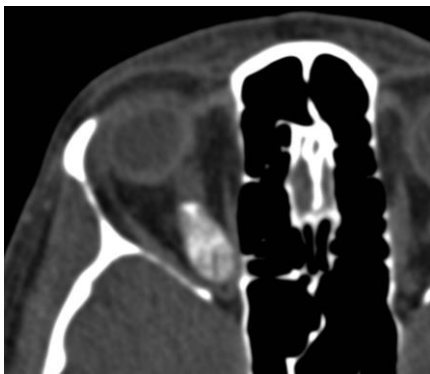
transverse non-enhanced CT, soft tissue window
